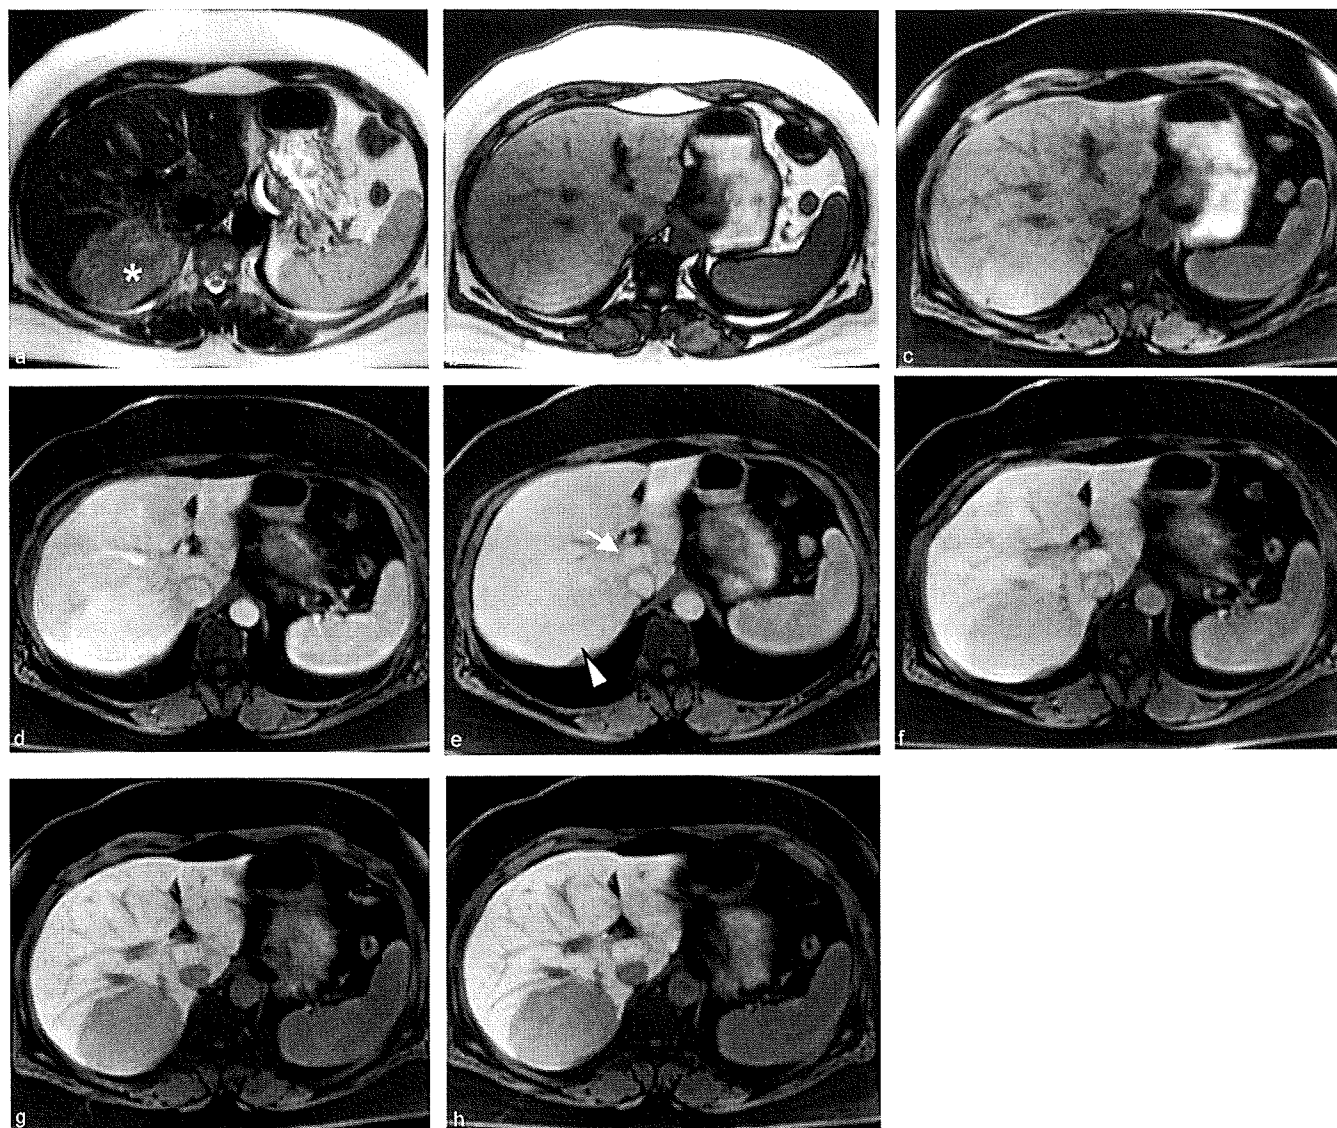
Appearance of typical hepatic adenoma (and associated FNH) during hepatocyte phase with Gd-EOB-DTPA-enhanced MRI (0.025 mmol/kg body weight). Unenhanced: a T2-weighted image, demonstrating large heterogeneous hyperintense lesion at hepatic segment VII (asterisk) and isointense nodule in the segment I. b T1-weighted out-phase image, c in phase, with both nodules appearing isointense. Dynamic Gd-EOB-DTPA-enhanced T1-weighted images on GRE 3D T1 (VIBE): d Arterial
